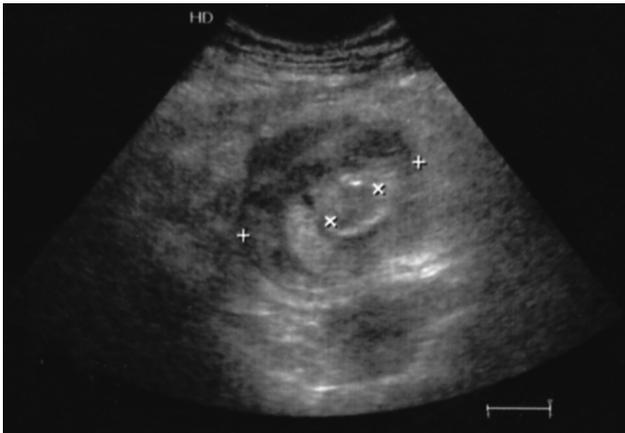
Transverse ultrasound imaging showing a "target sign"
